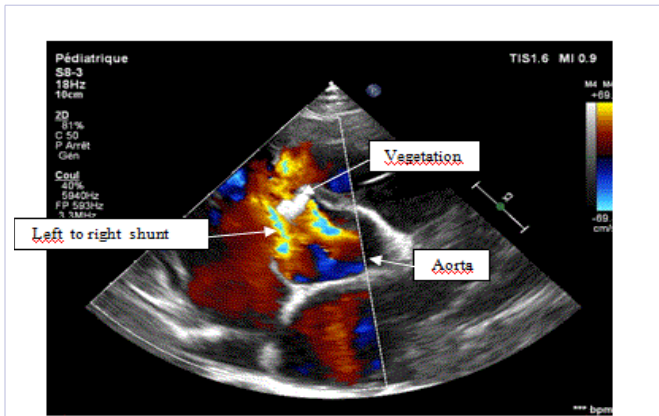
TTE Short axis parasternal view color mode showing vegetation and shunt
